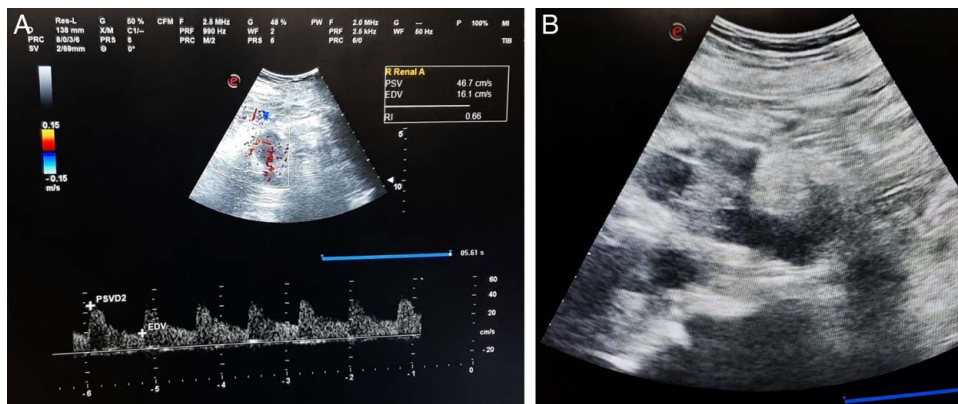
(A, B) Postoperative Doppler ultrasonography images of the right ectopic pelvic kidney two months after surgery. The images demonstrate its adequate blood flow and blood perfusion, which confirms the success of the surgery and the patency of the synthetic anastomotic grafts.
